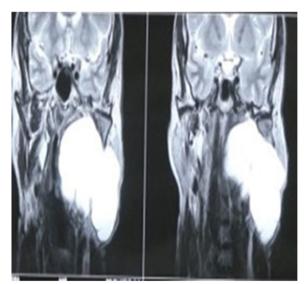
An enhancing lesion on magnetic resonance imaging that suggested a vascular tumor affecting the pre- and post-styloid compartment
